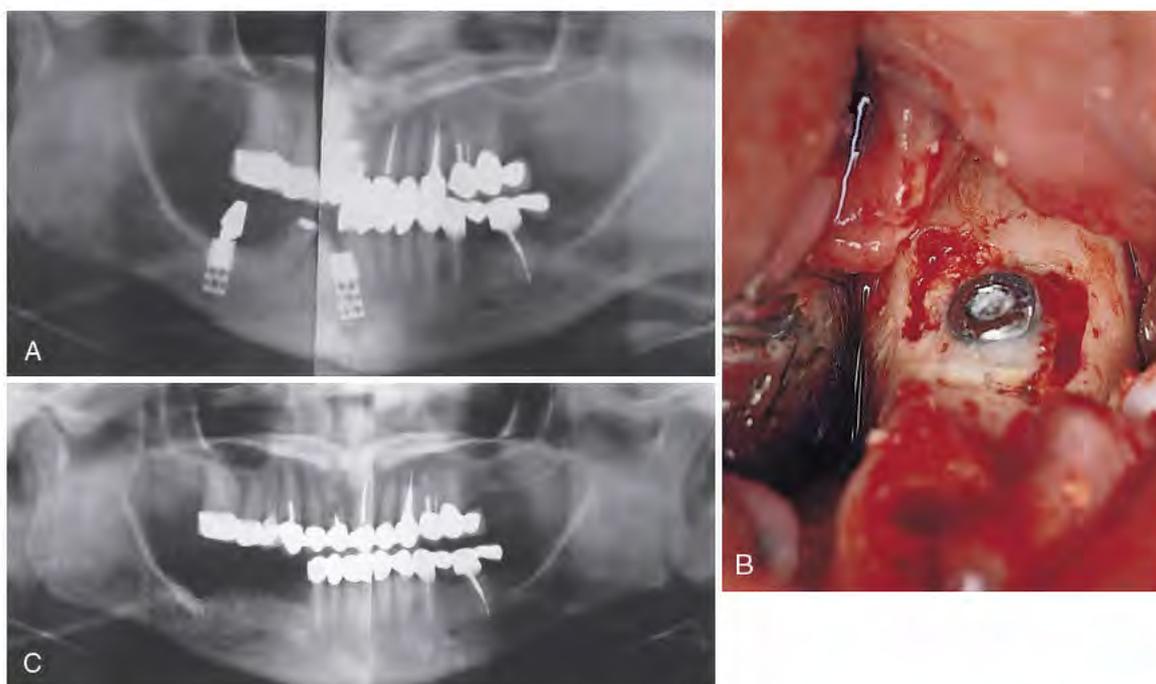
A, If a postinsertion paresthesia persists, the implant should be removed. This panoramic radiograph suggests proximity of the implant to the neurovascular bundle. B, This Core-Vent implant resisted removal even with reverse use of the ratchet wrench. It required en bloc removal because of osseointegration. C, A postoperative radiograph shows the grafted host site. To ensure that no particles communicated with vital tissues, a barrier (Colla-Cote) was used at the base of the osteotomy before the graft material was placed.
